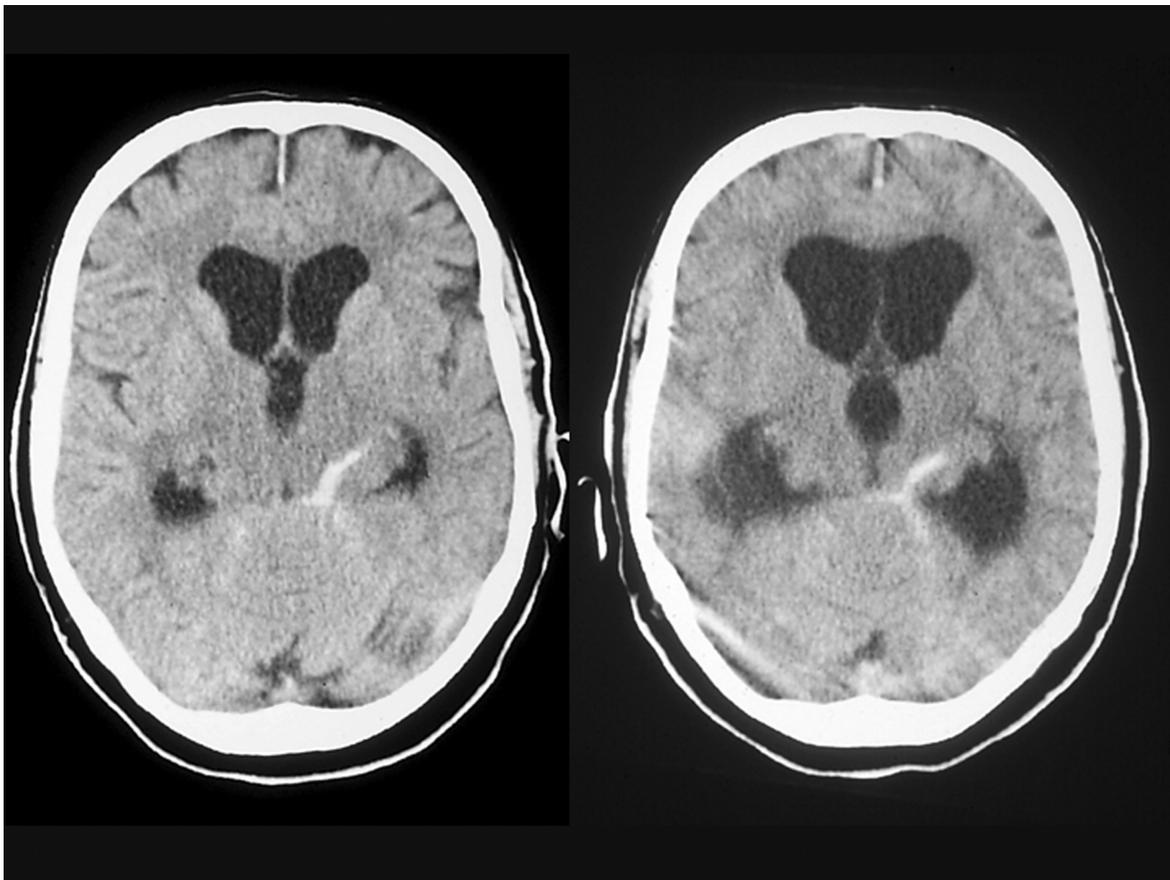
Acute hydrocephalus. CT scans of the brain of a 74-year-old woman admitted because of a severe and sudden headache, 6 hours (a) and 15 hours (b) after symptom onset. Initially she was disoriented but alert, but in the interval her level of consciousness gradually decreased, while the pupils became small and unreactive, with downward deviation of the eyes. The ventricular system is enlarged on the first scan (frontal horns, temporal horns, and third ventricle are visible) but even more on the repeat study
